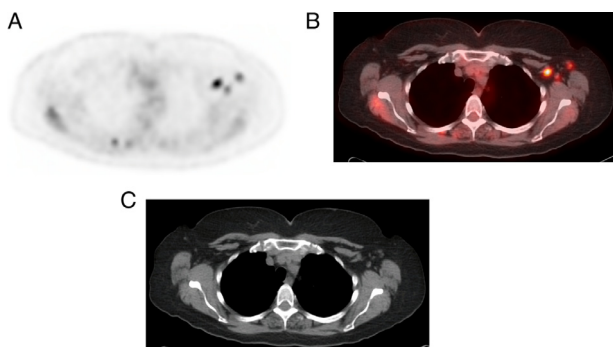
62-year-old female presenting for restaging PET-CT. Axial PET and fused PET-CT images (A and B) demonstrated hypermetabolic left axillary lymph nodes. Axial CT image (C) demonstrated multiple axillary lymph nodes not enlarged by CT criteria. No hypermetabolic sites of metastasis were identified elsewhere throughout the body. Note that the patient's FDG injection was right-sided. After additional history was asked of the patient, it was noted that the patient had received their first COVID-19 vaccine dose 1 week before the PET-CT with that injection occurring in the left deltoid. The finding was reported as reactive lymphadenopathy from recent vaccination.
